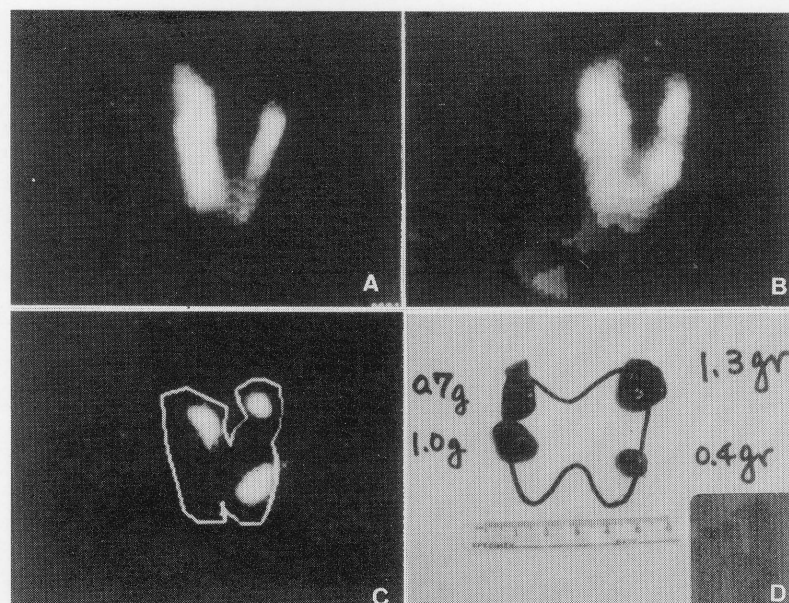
Procedure for parathyroid subtraction scintigraphy using  $^{201}\text{Tl}$  and  $^{131}\text{I}$ .
